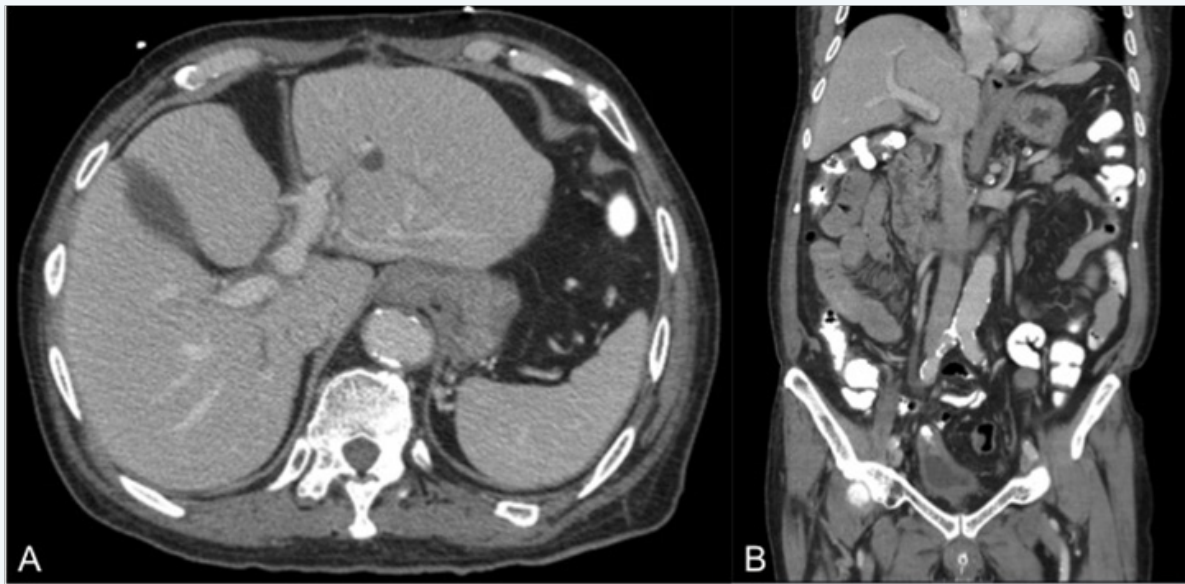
CT of the abdomen and pelvis with oral contrast on hospital day 6.
